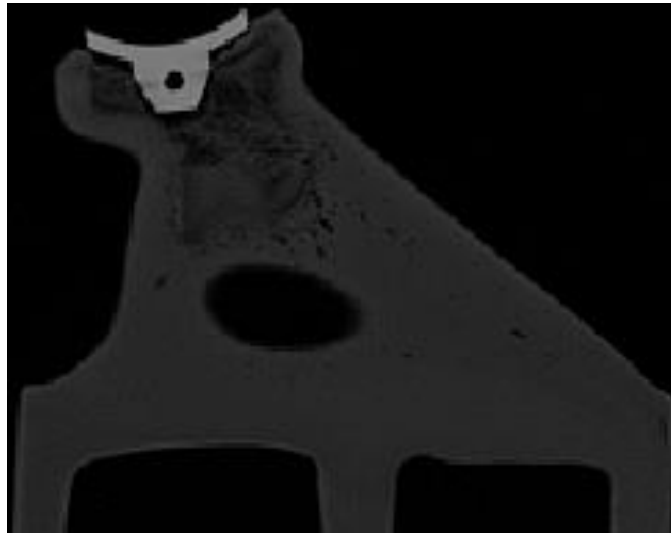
CT scan for robot prepared uncemented standard keel implant
